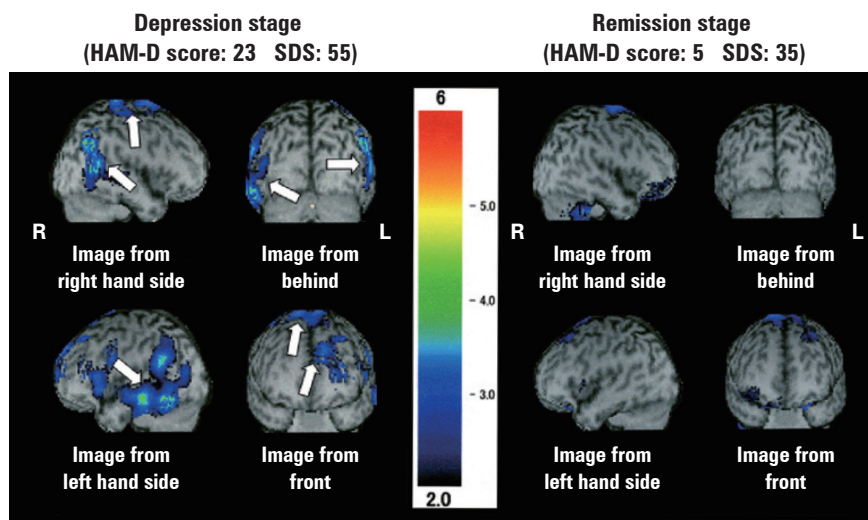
Examination of the cerebral blood flow using ^{99m}Tc-ECD SPECT imaging
